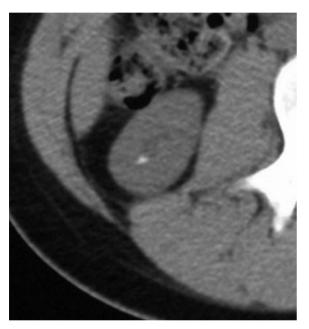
Low-dose CT in nephrolithiasis, not diagnosed by US. A 14-year-old girl
